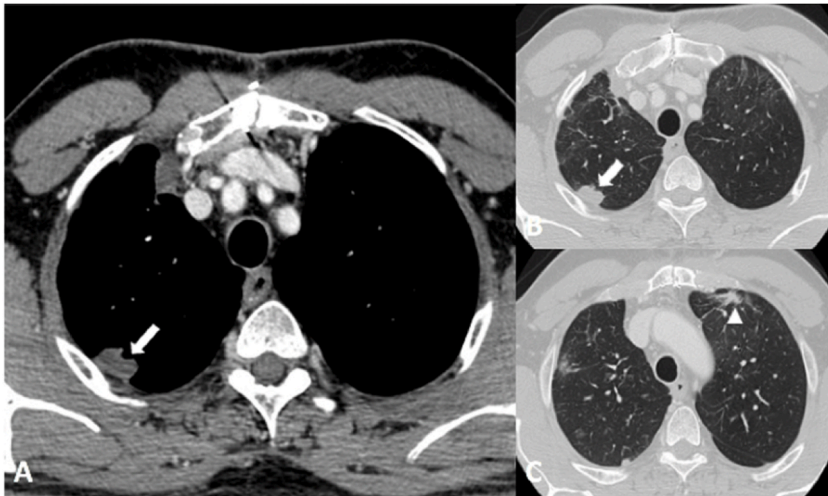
Follow-up CT evaluation. Some areas of parenchymal consolidation, with irregular margins and adhering to the costal pleura, are appreciated in the dorsal segment of the upper right lobe (white arrows in A and B) and in the anterior segment of the upper left lobe (arrowhead in C). These alterations correspond to repetitive lesions of the disease.
